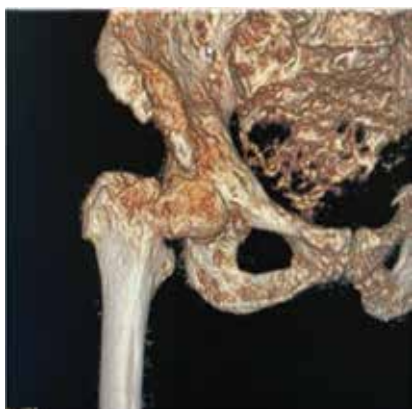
Computed axial tomography (CT) of the hip with 3D reconstruction.
